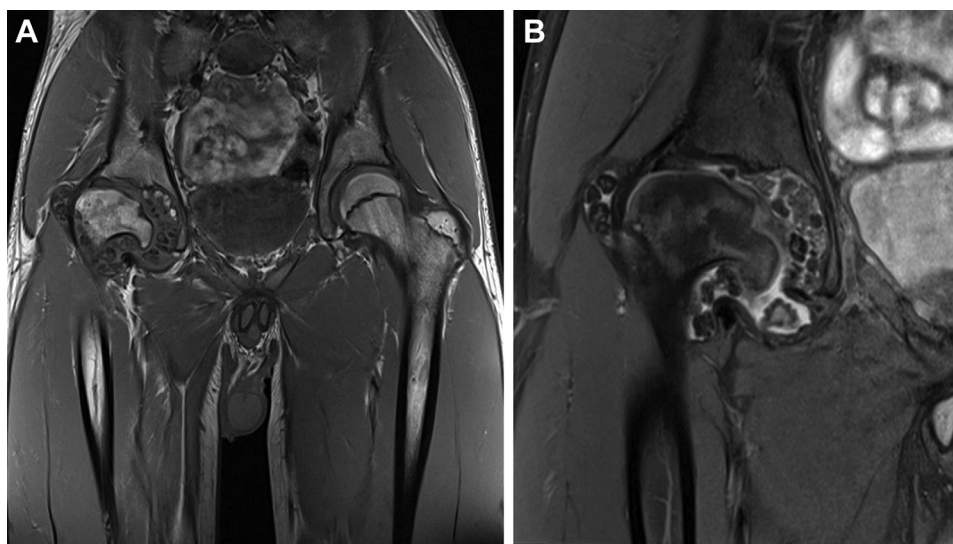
Coronal magnetic resonance imaging images on T1 (A) and proton density fat suppression (B) at 11 years of age show multiple intraarticular calcified round bodies of similar size with low signal intensity in all sequences around the head of the right femur.
